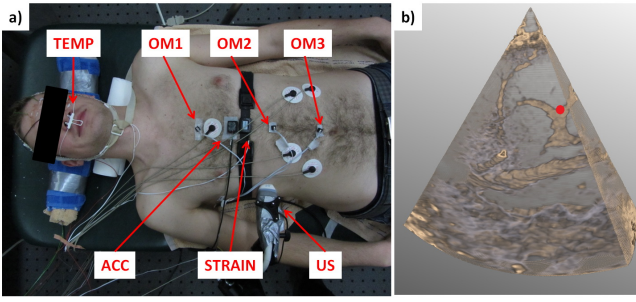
a) Sensor setup: temperature sensor (TEMP), optical marker 1-3 (OM 1-3), acceleration sensor (ACC), strain sensor (STRAIN) and ultrasound transducer (US). b) Example of an ultrasound image and the selected landmark (red dot).
